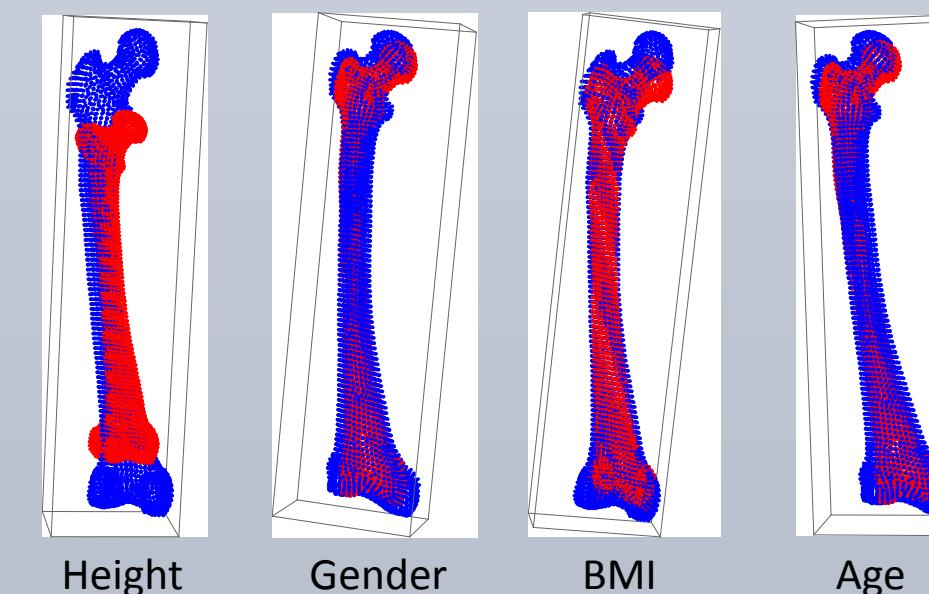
Images showing the effects of varying height, gender, BMI, and age on femur shape over the ranges present in the CT dataset while holding other parameters constant.
